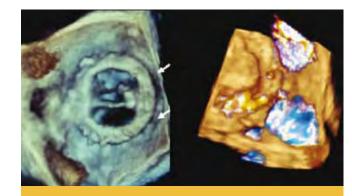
Left image St Jude's bi-leaflet mechanical valve with bannus formation over leaflets and two large regions of valve dehiscence (white arrows). Right image depicts paravalvular regurgitation identified with 3-D colour Doppler.
